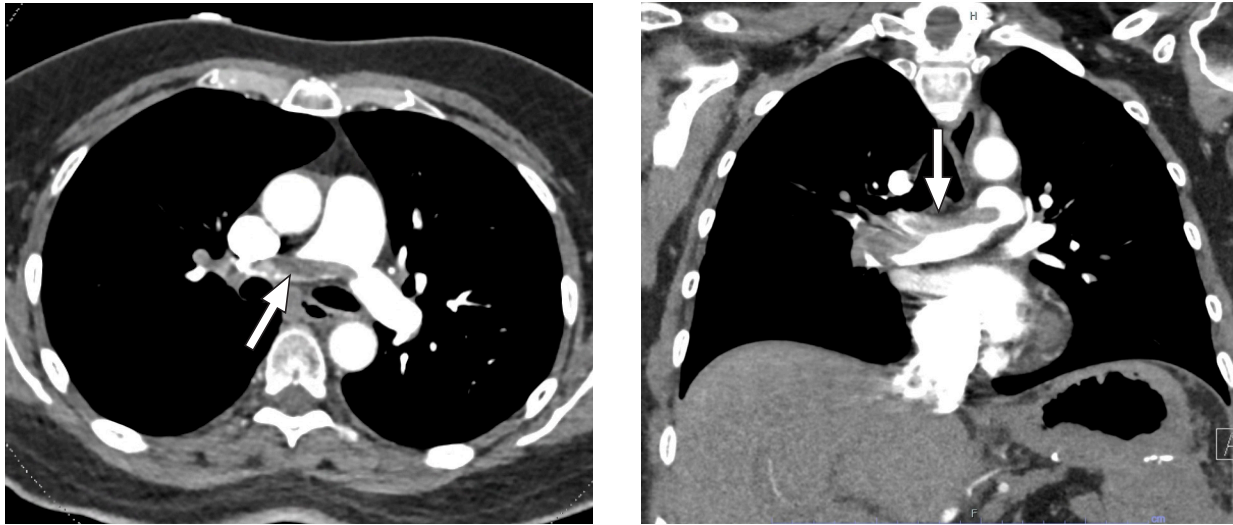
A) Transverse and B) coronal computed tomography with angiography images of the pulmonary artery show a large pulmonary embolus extending from the left pulmonary artery to the right pulmonary artery (arrows).
